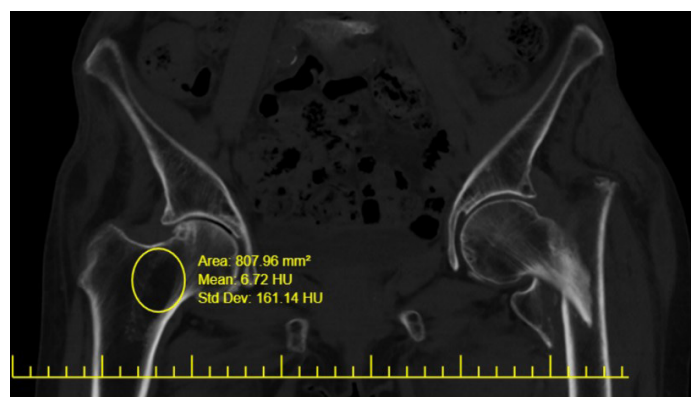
CT evaluation of the patient's healthy hip at the time of admission with fracture
